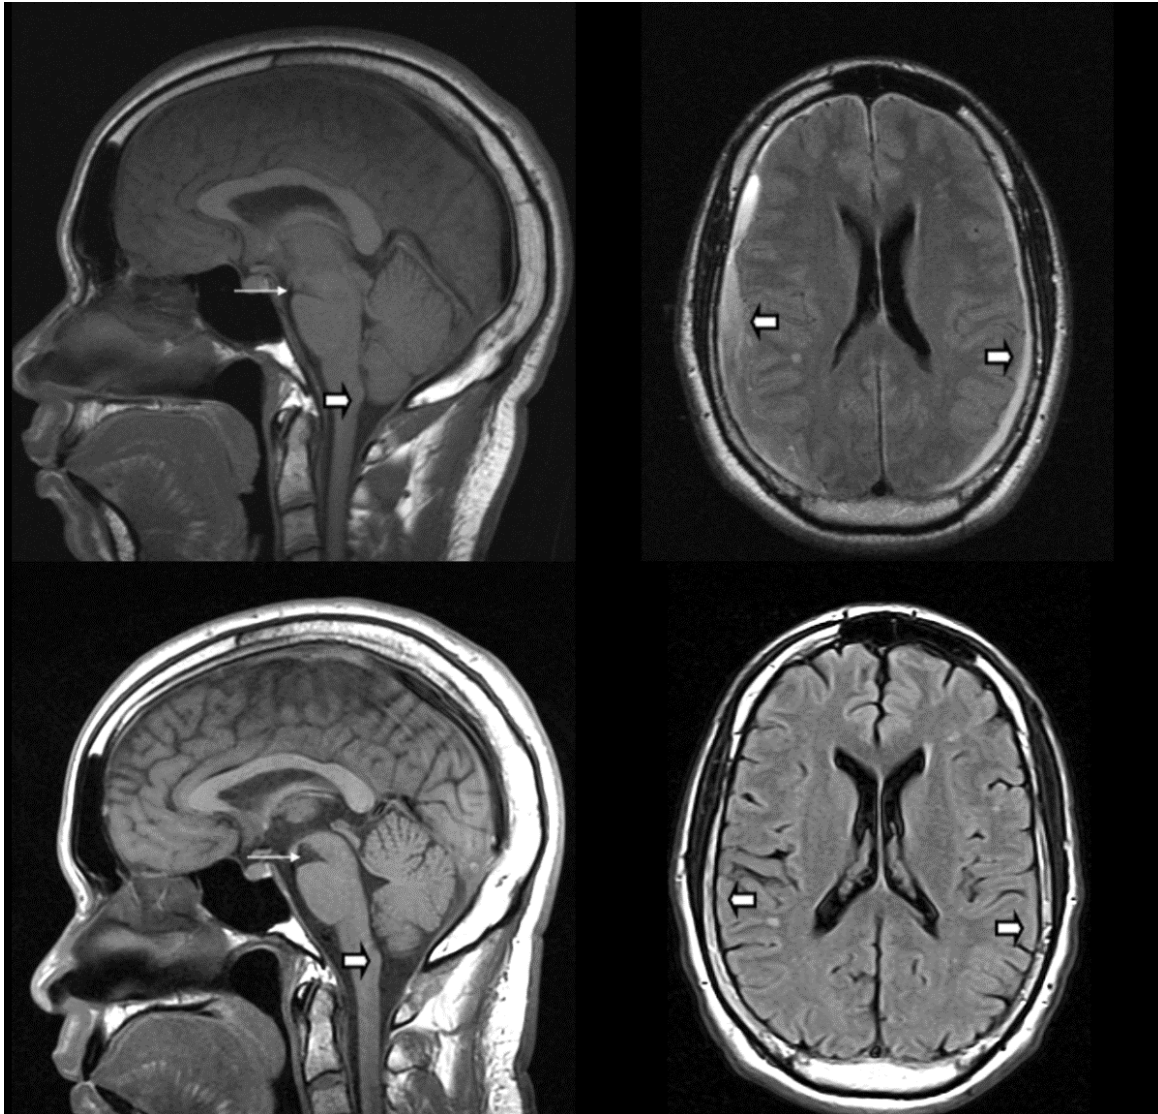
A patient with intracranial hypotension. Initial sagittal T1 MRI image (top left) demonstrates decrease in the midbrain-pontine angle (thin arrow) and mild crowding at the foramen magnum (short arrow). There are bilateral subdural collections overlying the cerebral convexities on an Axial FLAIR image (top right image - short arrows). Follow up MRI sagittal T1 image (bottom left) after resolution of symptoms demonstrates increase in the midbrain-pontine angle (thin arrow) and resolution of the crowding at the foramen magnum (short arrow). An Axial FLAIR image (bottom right) also demonstrates resolution of the bilateral subdural collections (short arrows).
